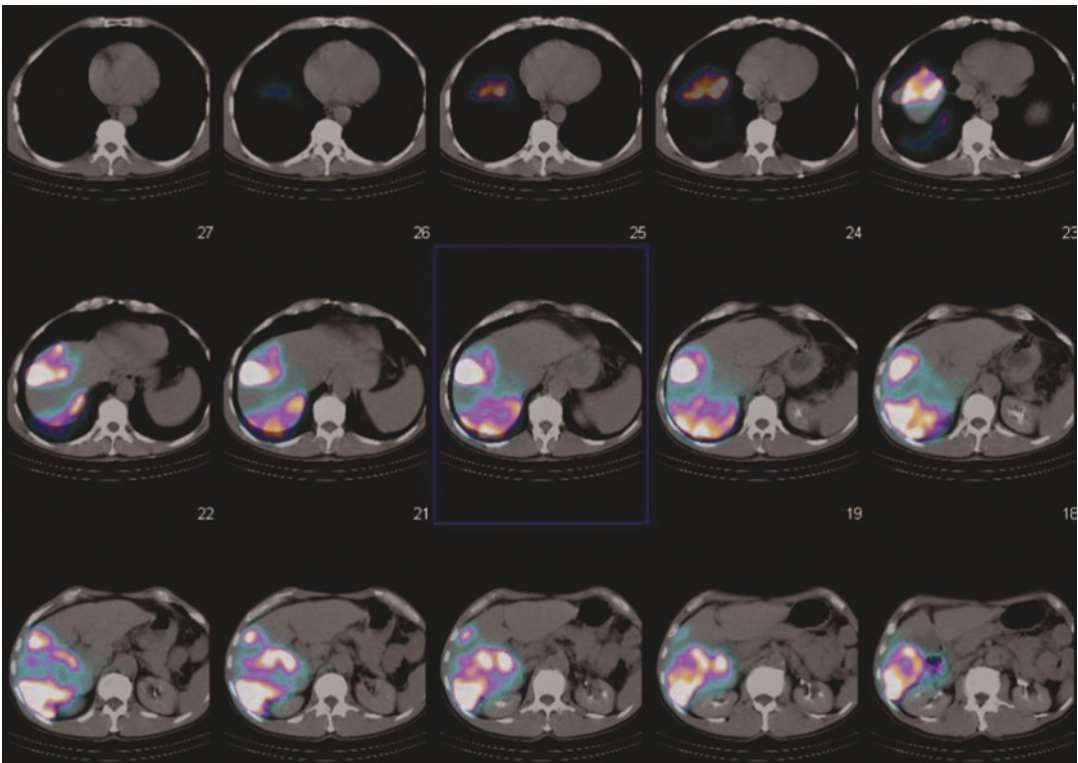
A SPECT-CT confirming the uptake in the right lobe of liver, without extrahepatic deposition of particles
